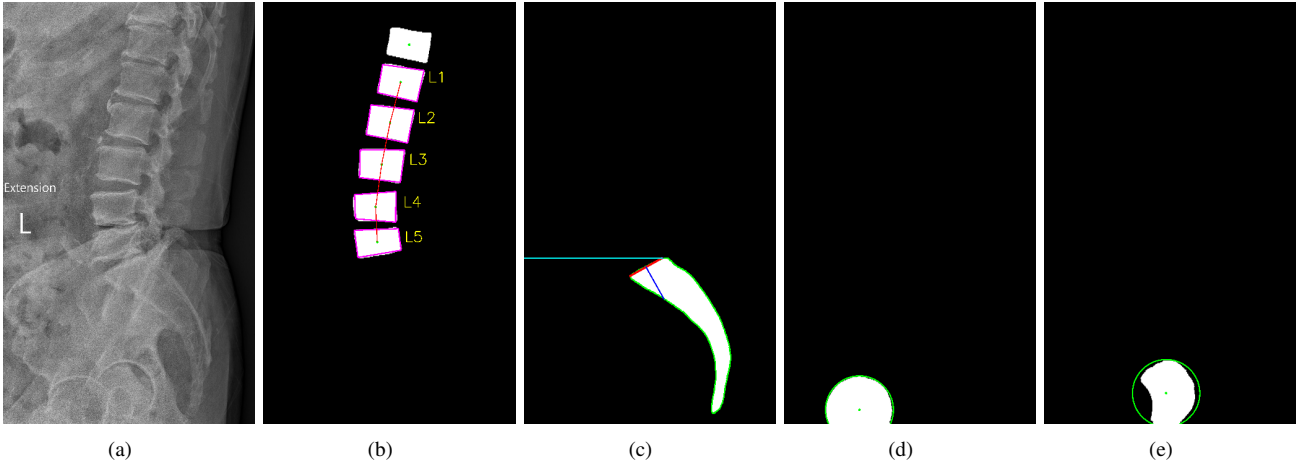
An overview of the localization of lumbar vertebra and the shape fitting of lumbar vertebrae spine, sacrum, and two femoral heads presented in four layers. (a) the input X-ray image, (b) the first layer processing the lumbar vertebra from  $L1$  to  $L5$  and detecting five quadrilaterals of lumbar vertebra (in purple), (c) the second layer processing the sacrum (green contour) and the sacral endplate  $S1$  (red line), with the blue line perpendicular to the center of  $S1$  and the cyan line aligned with the sacral endplate, (d), (e) the layers of two femoral heads (green circles).
